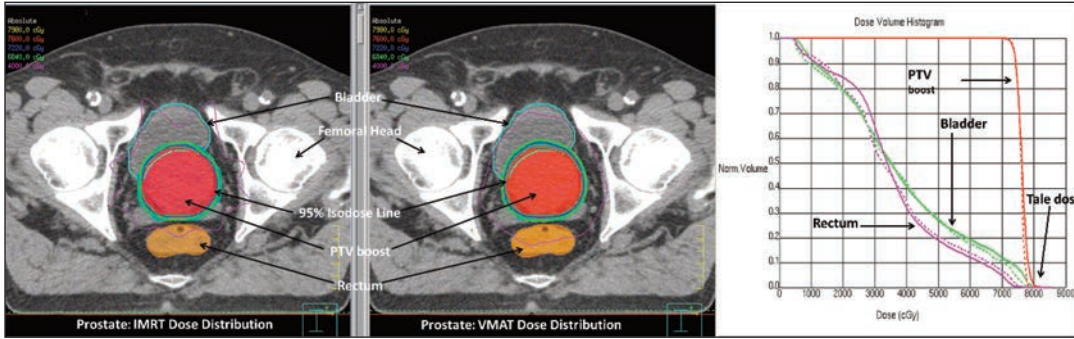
A representative case of prostate dose distribution in specific computed tomography (CT) slice for intensity modulated radiotherapy (IMRT) and volumetric modulated arc-therapy (VMAT). The thick green isodose line in left and middle images represents 90% of prescribed dose (PD), and thin blue isodose line represents 95% of PD covering whole of the PTVboost. Dose-volume histograms (DVH) on the right side shows planning target volume (PTV) and organs at risk (OAR) (bladder and rectum). Solid-lines represent VMAT, and dotted lines represent IMRT results.
